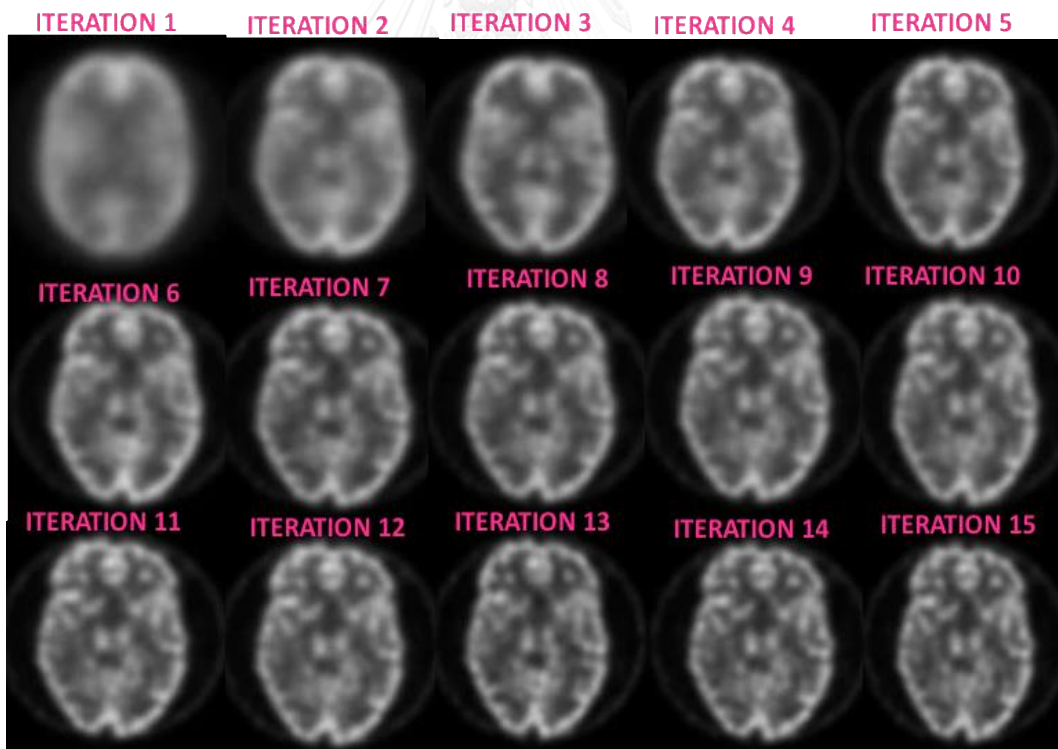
Figure B 5. The brain SPECT images by varying number of iterations in high activity concentration (3D- OSEM)
